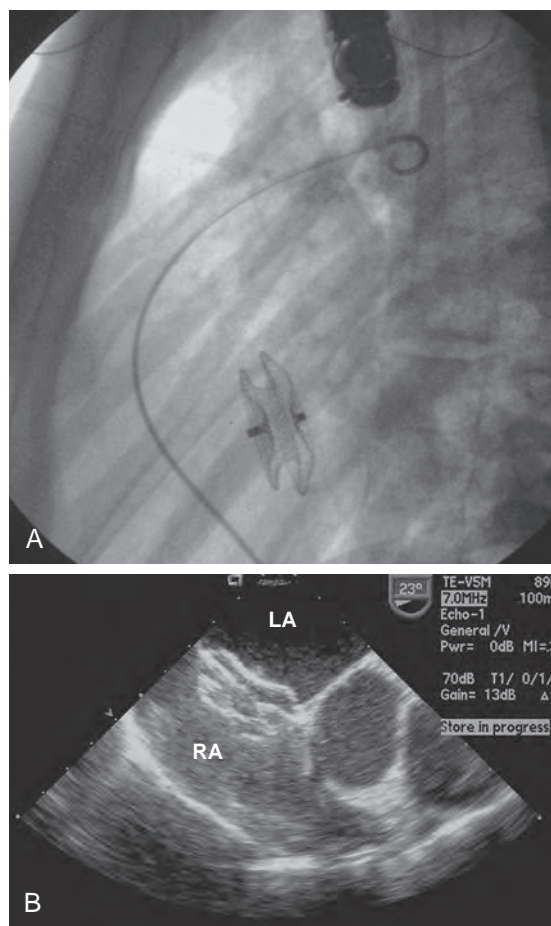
Closure of an atrial septal defect in an adult with use of a transvascular device (the Amplatzer septal occluder). (A) Radiograph. (B) Transesophageal echocardiogram. The device is clearly visualized spanning and occluding the atrial septal defect. RA, Right atrium; LA, left atrium. (Courtesy Dr. Scott Lim.)
